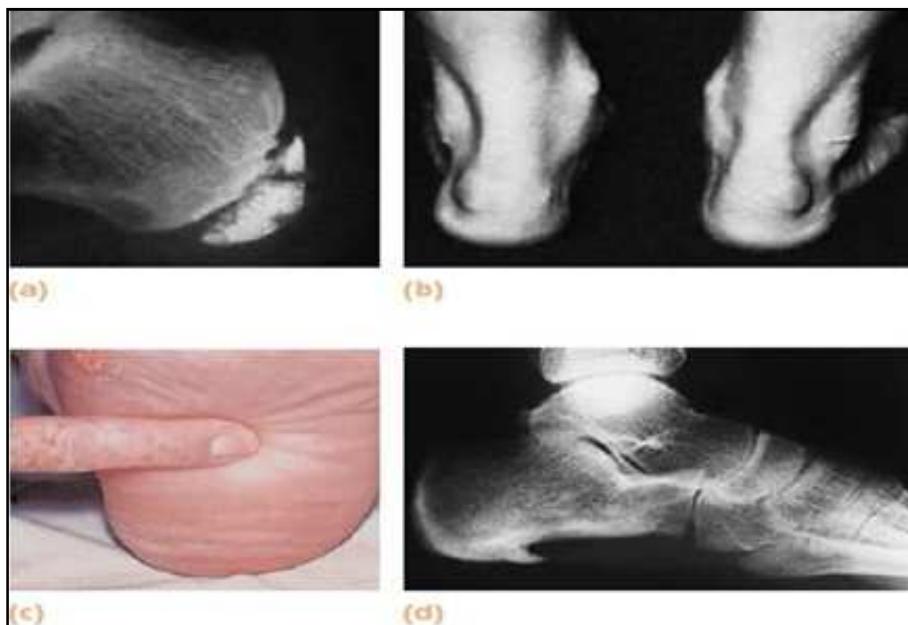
Painful heel (a) Sever’s disease – the apophysis is dense and fragmented. (b) Bilateral ‘heel bumps’. (c) The usual site of tenderness in plantar fasciitis. (d) X-ray in patients with plantar fasciitis often shows what looks like a spur on the undersurface of the calcaneum. In reality this is a two-dimensional view of a small ridge corresponding to the attachment of the plantar fascia. It is doubtful whether the ‘spur’ is responsible for the pain and local tenderness.
